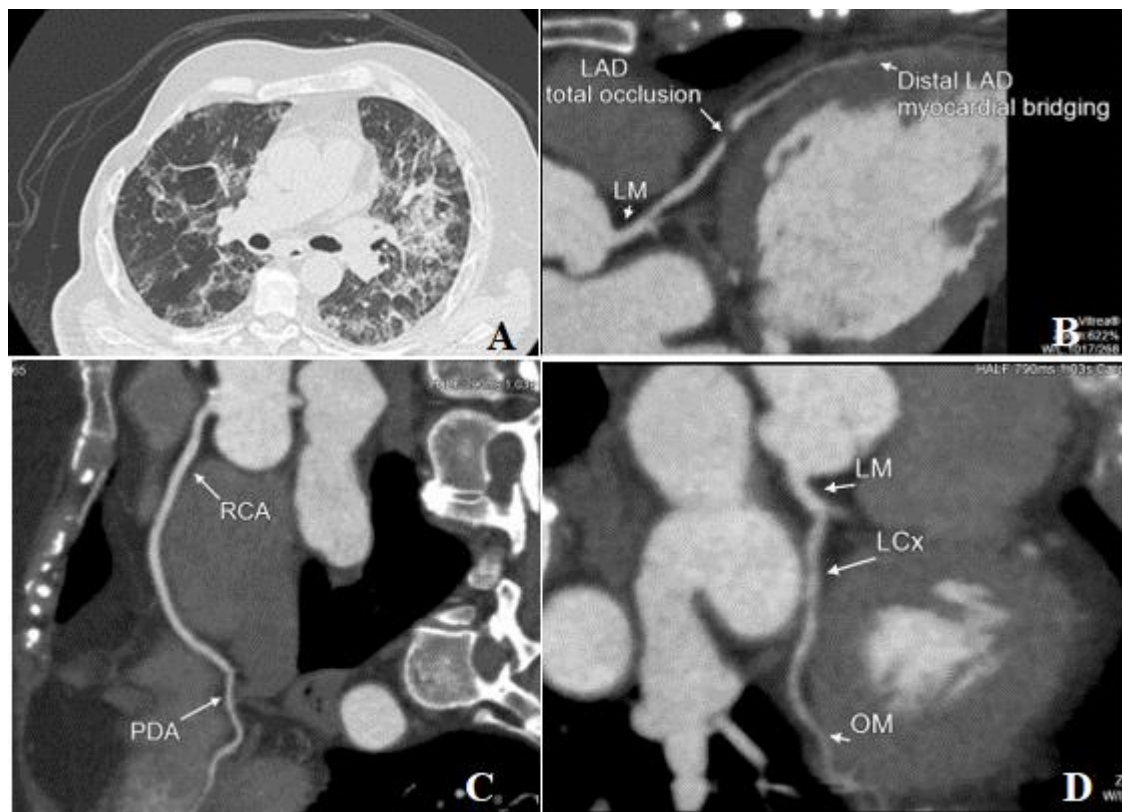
Female patient aged 40 years old, with CT chest findings (CORAD-5) and severity score =23; a few days later, she developed chest pain and dyspnoea symptoms. A) Axial CT chest (lung window) showing multiple patches of ground glass opacities with subpleural fibrotic bands (B) curved MPR 2D image reveals soft concentric plaque at mid-segment of LAD opposite D2 (the second diagonal branch) take off, exerting total LAD occlusion, (C, D) curved MPR show free RCA, LM & Lcx. The diagnosis was Focal mid-segment LAD total occlusion
